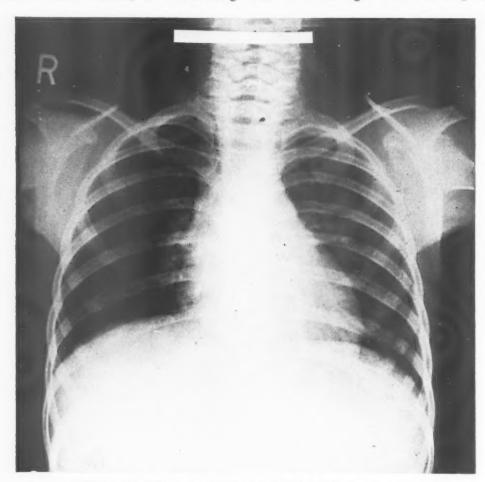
Nineteen days after second asthmatic attack showing a normal chest x-ray.
